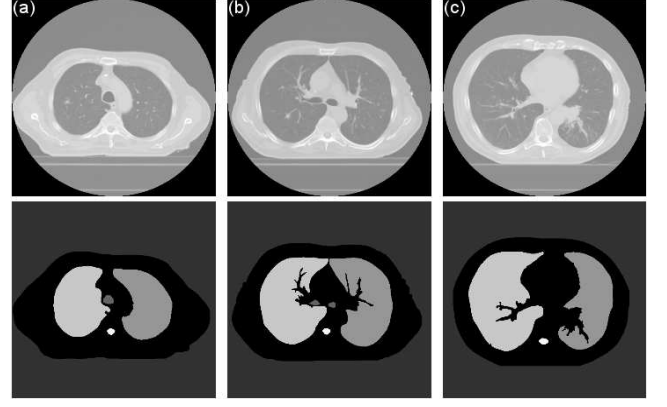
CT thoracic image segmentation of body, lungs and trachea: (a) Slice 17, (b) Slice 27, (c) Slice 39.
